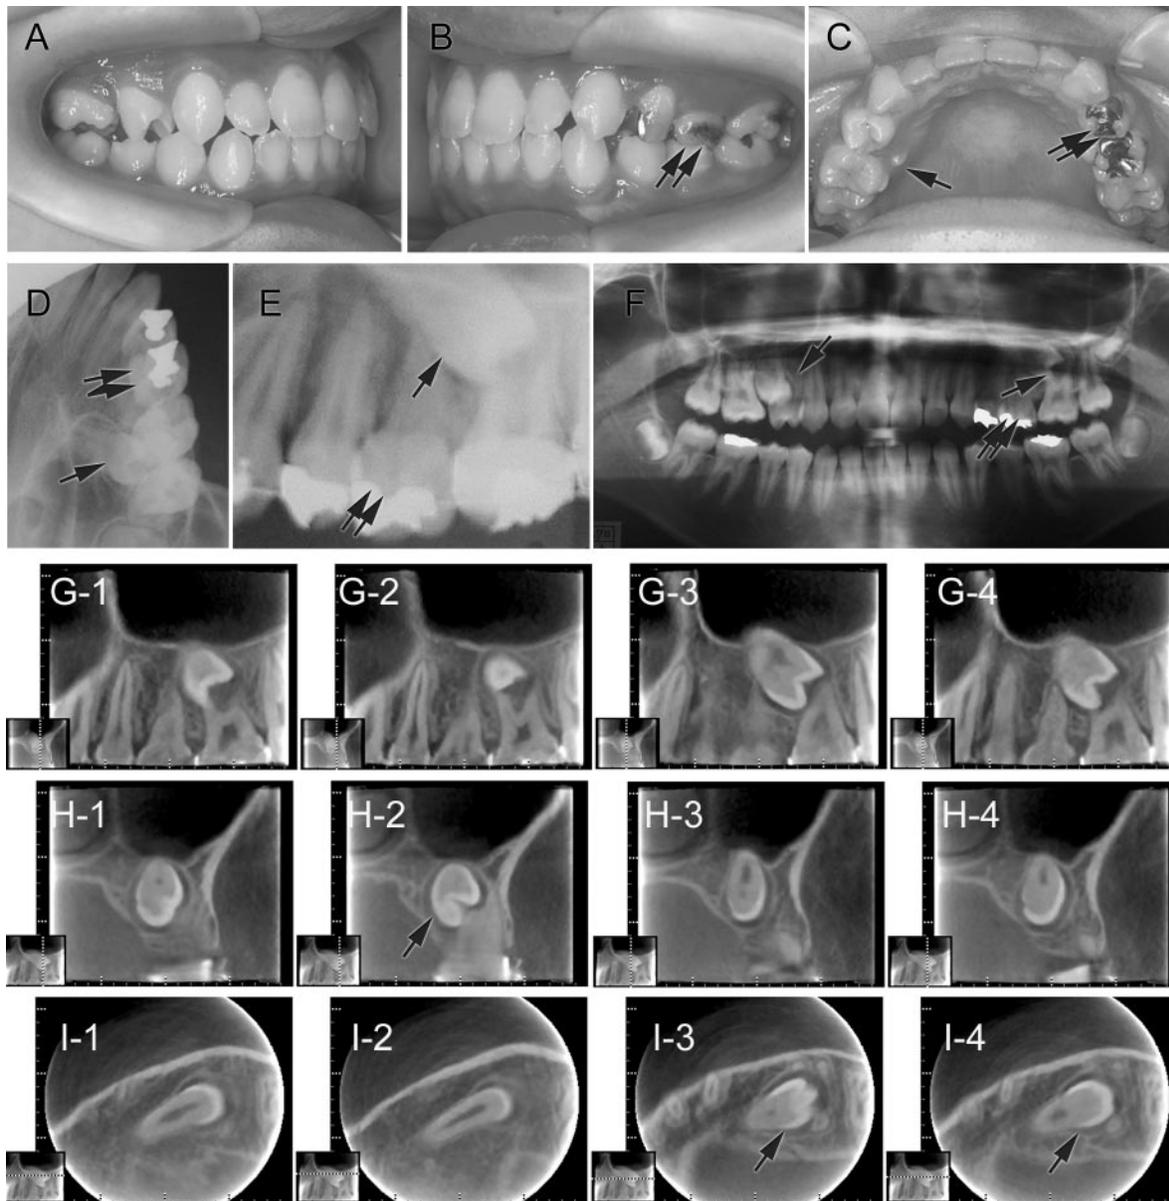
Case 2: (A–C) Oral photograph. (D) Occlusal radiograph. (E) Dental radiograph. (F) Panoramic radiography. (G 1–4) Sagittal images. (H 1–4) Frontal images. (I 1–4) Axial images. All single arrows indicate impacted second premolar and double arrows indicate the left second deciduous molar.
